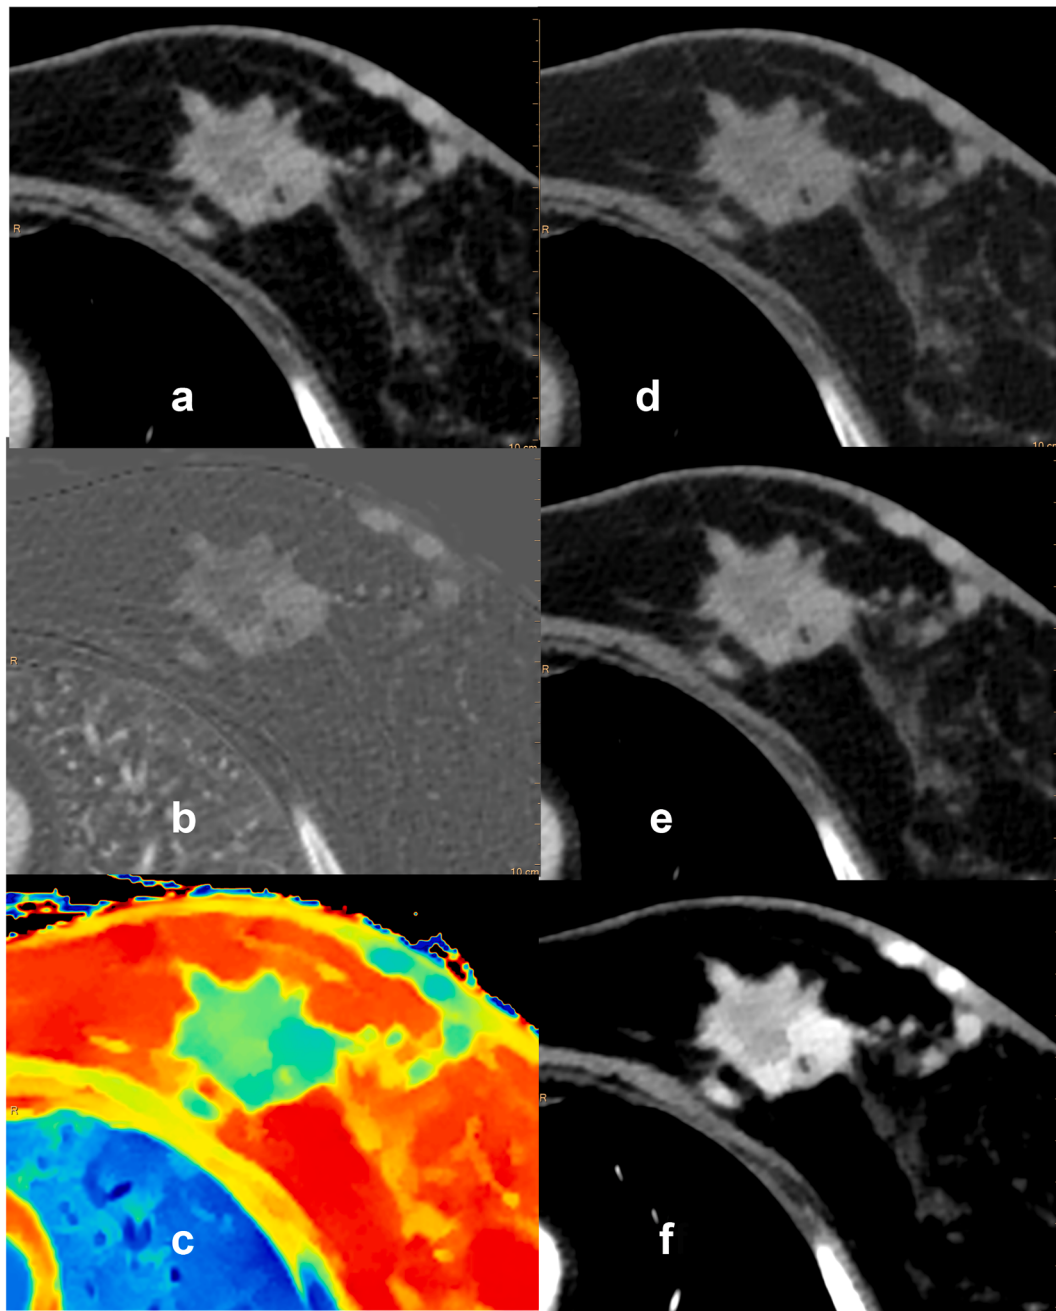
71-year-old female patient with an invasive ductal carcinoma, G2, luminal A-type, Ki-67 14%, cT4b, cN1, cM1 with lung and liver metastases proven by ultrasound-guided biopsy. (a) The conventional CT images show an inhomogeneous solid tumor of 3.7 cm maximum diameter and a mean density of 91.4 HU in its most contrast-absorbing portion. (b) The mean iodine content determined in the iodine-map was 2.18 mg/ml and (c) the mean Z-effective value was 8.45. The density values determined from the virtual monoenergetic image series are as follows: (d) 58.5 HU at 100 keV, (e) 90.03 HU at 70 keV and (f) 220.3 HU at 40 keV.
